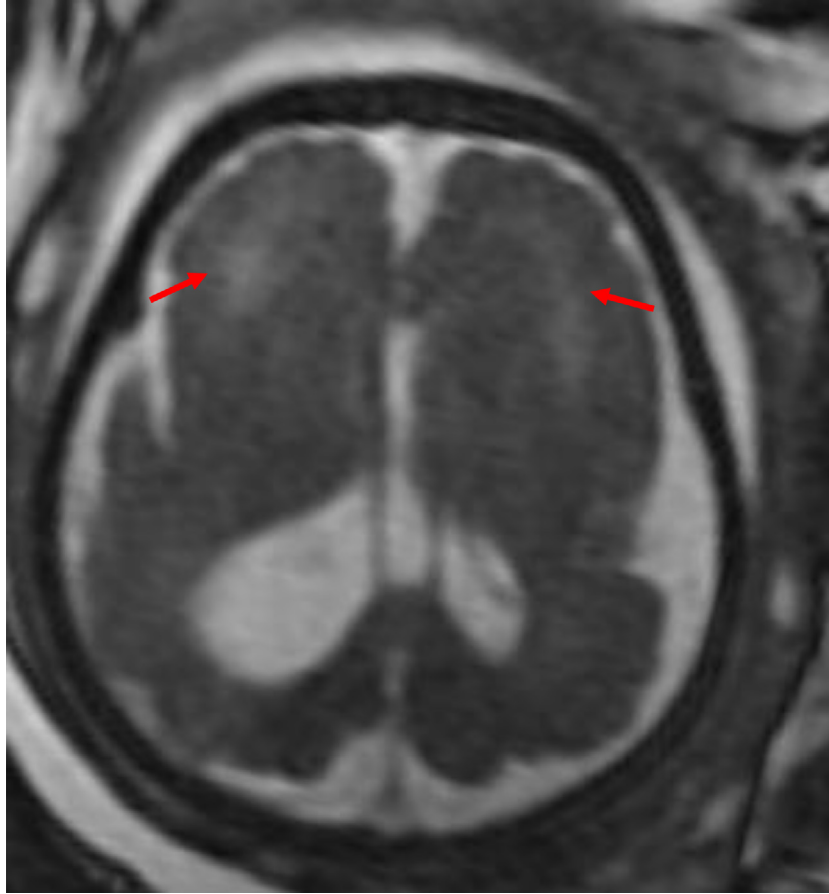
Axial FIESTA T2 fetal MRI at 35 wk GA demonstrating bilateral white matter signal abnormality within the bifrontal lobes (red arrows). GA, gestational age. “Color version available online.”
